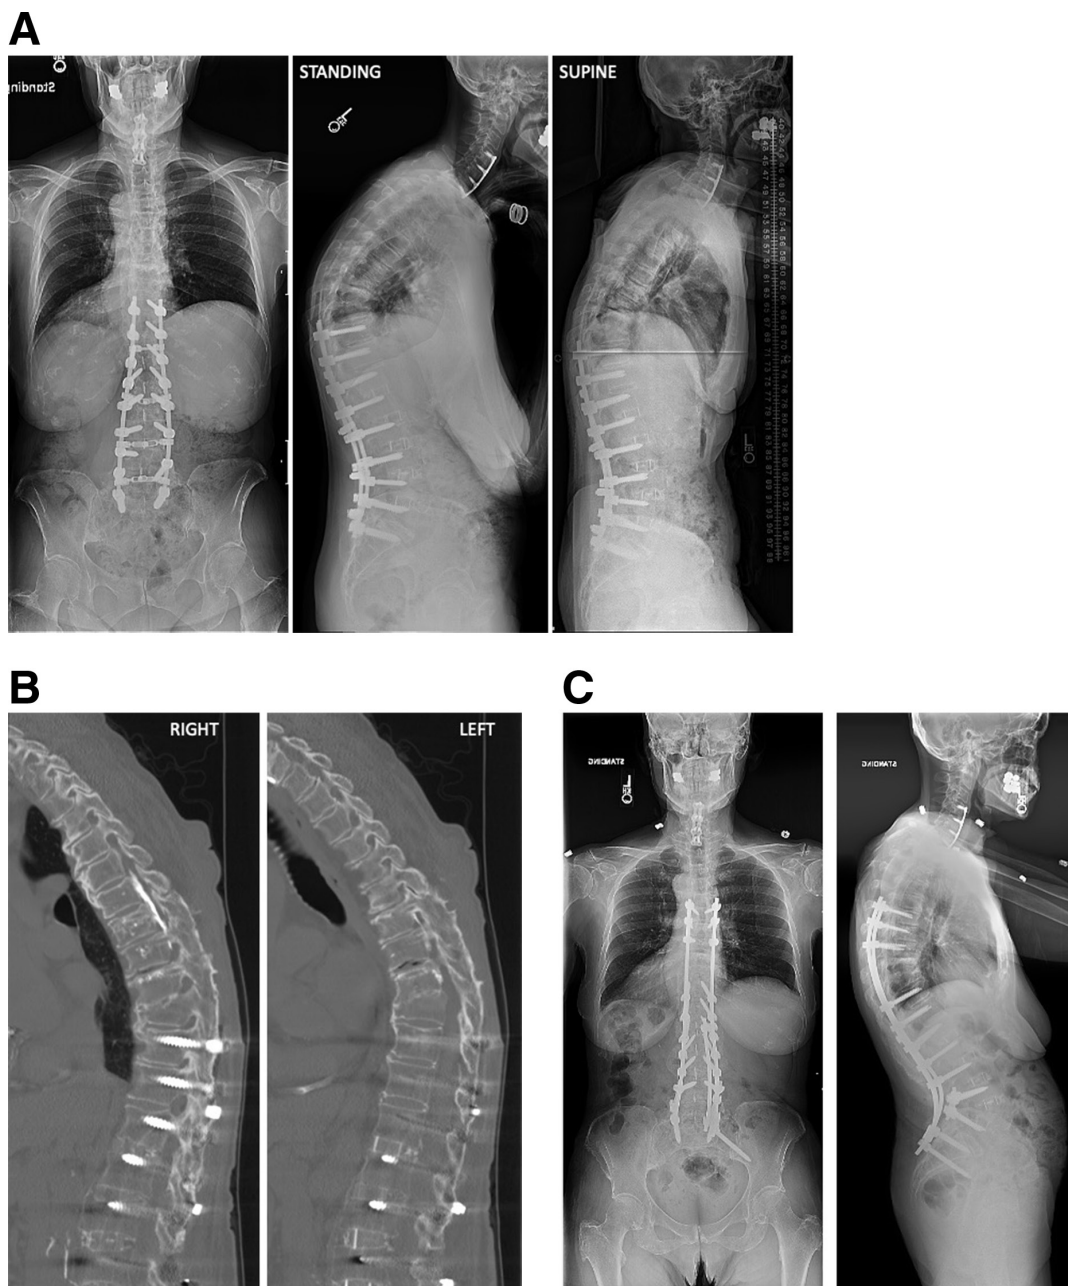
(A). Preoperative x-ray images showed lucencies around pelvic instrumentation and pedicle screw pullout/loosening at T4-T6 with spondylolisthesis at T3-T4. Alignment parameters showed a low-grade PI, no significant PI-LL mismatch, and elevated pelvic tilt: PI 37°, LL 28°, PI-LL 9°, PT 27°, TK 63°, and SVA 23 mm. (B) Computed tomography images showed lucencies around pedicle screws T4-T6 and pedicle screw pullout with spondylolisthesis T3-T4 and L5-S1 pseudarthrosis. (C) 6-month postoperative x-ray images after revision posterior spinal fusion with instrumentation T2-pelvis and L3 pedicle subtraction osteotomy. Alignment parameters show that the pelvic tilt has normalized. PI 37°, LL 53°, PI-LL -16°, PT 14°, TK 63°, and SVA -44 mm. PI, pelvic incidence; LL, lumbar lordosis; PI-LL, PI LL mismatch; PT, pelvic tilt; TK, thoracic kyphosis; SVA, sagittal vertical axis
